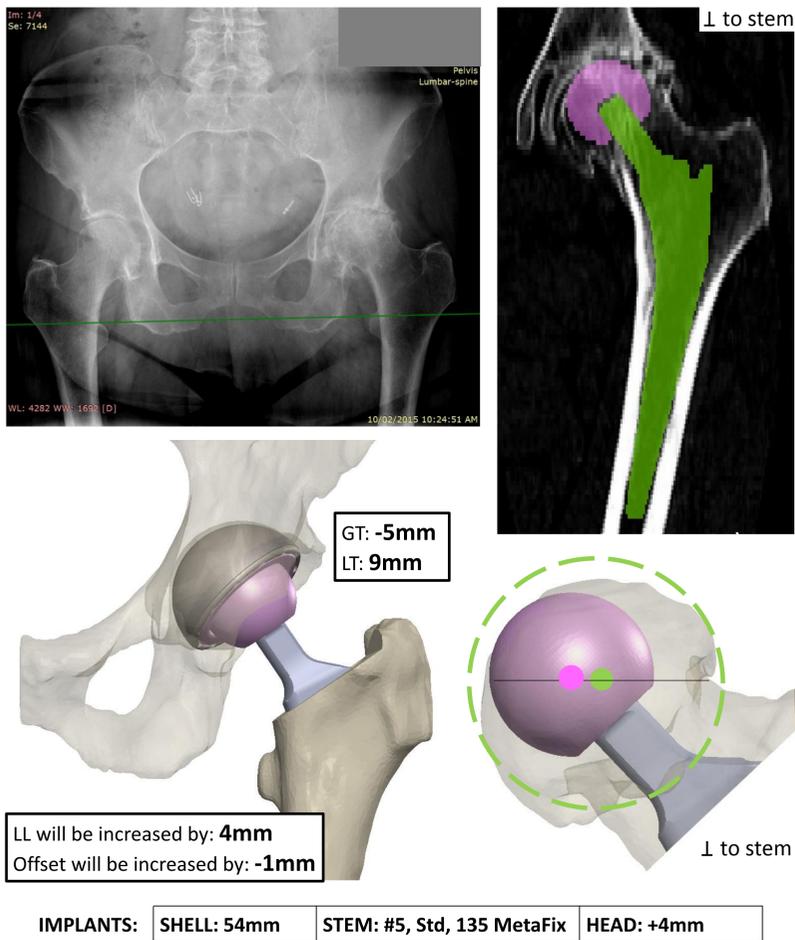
Optimized Ortho OPS planning algorithm involves 3D templating from CT to recreate the native head height. The surgeon can elect to alter the plan, if required
